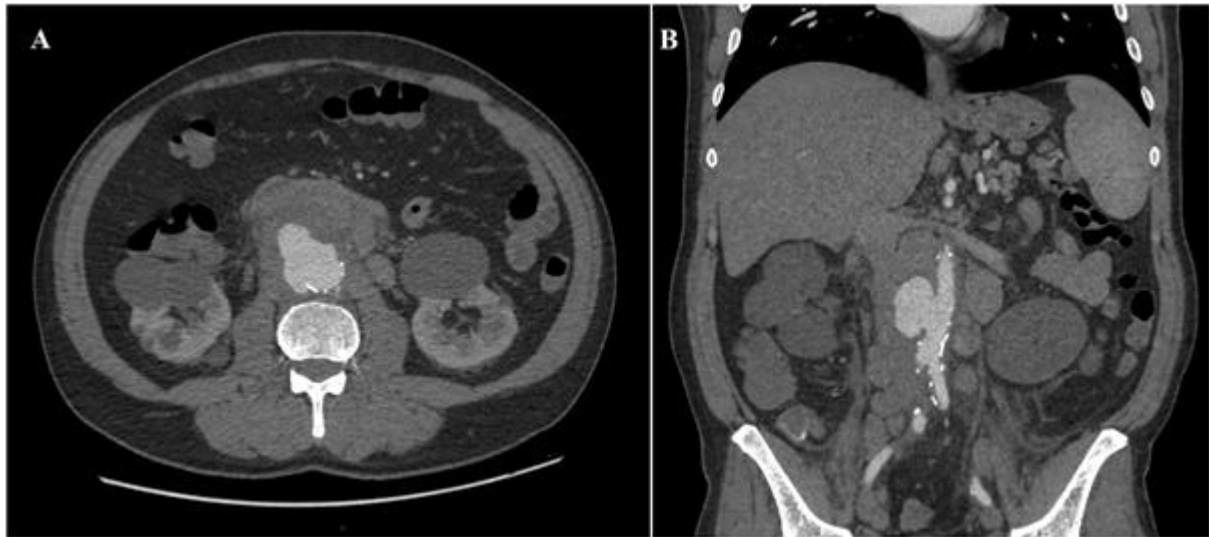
Initial contrast-enhanced computed tomography examination of the abdomen: A – axial image; B – coronal image; a conglomerate of enlarged lymph nodes is observed in the periaortic and retroperitoneal region, with a small amount of locoregional free fluid
